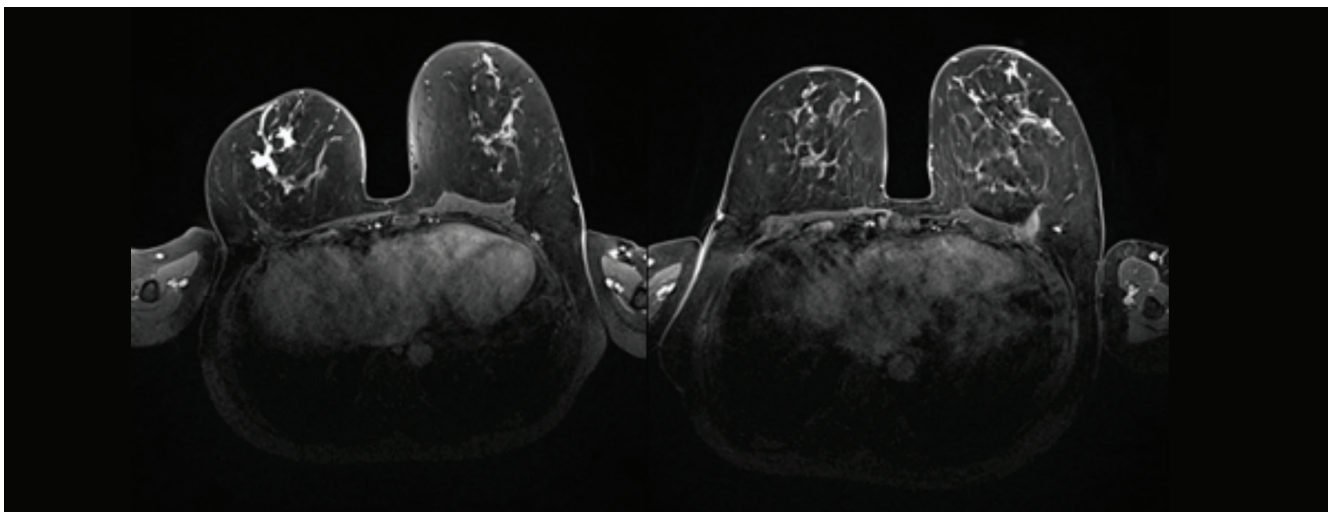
MRI demonstrating clinical complete response (cCR) of recurrent node positive TNBC in the right breast to NST that included Carboplatin and Pembroluzimab in a 50-year old woman (left: before NST; right: after NST. The patient achieved pCR.
